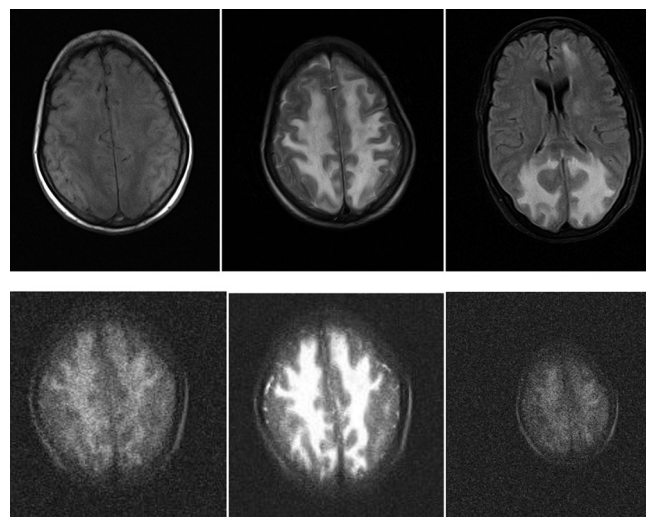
T1, T2, flair and DWI showing PML in a case of AIDS – diffuse confluent hypointense lesions involving both parietal and occipital lobes which are hypointense in T1 and hyperintense in T2, flair and DWI images.
